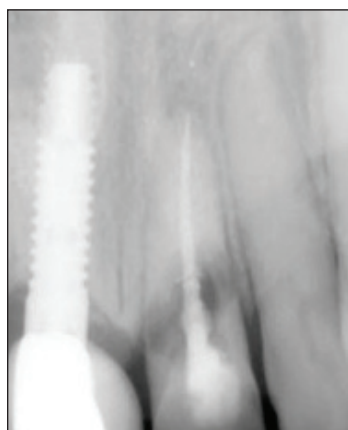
An x-ray of a maxillary central incisor with internal resorption and a 6-year postop implant replacing the other central incisor.
